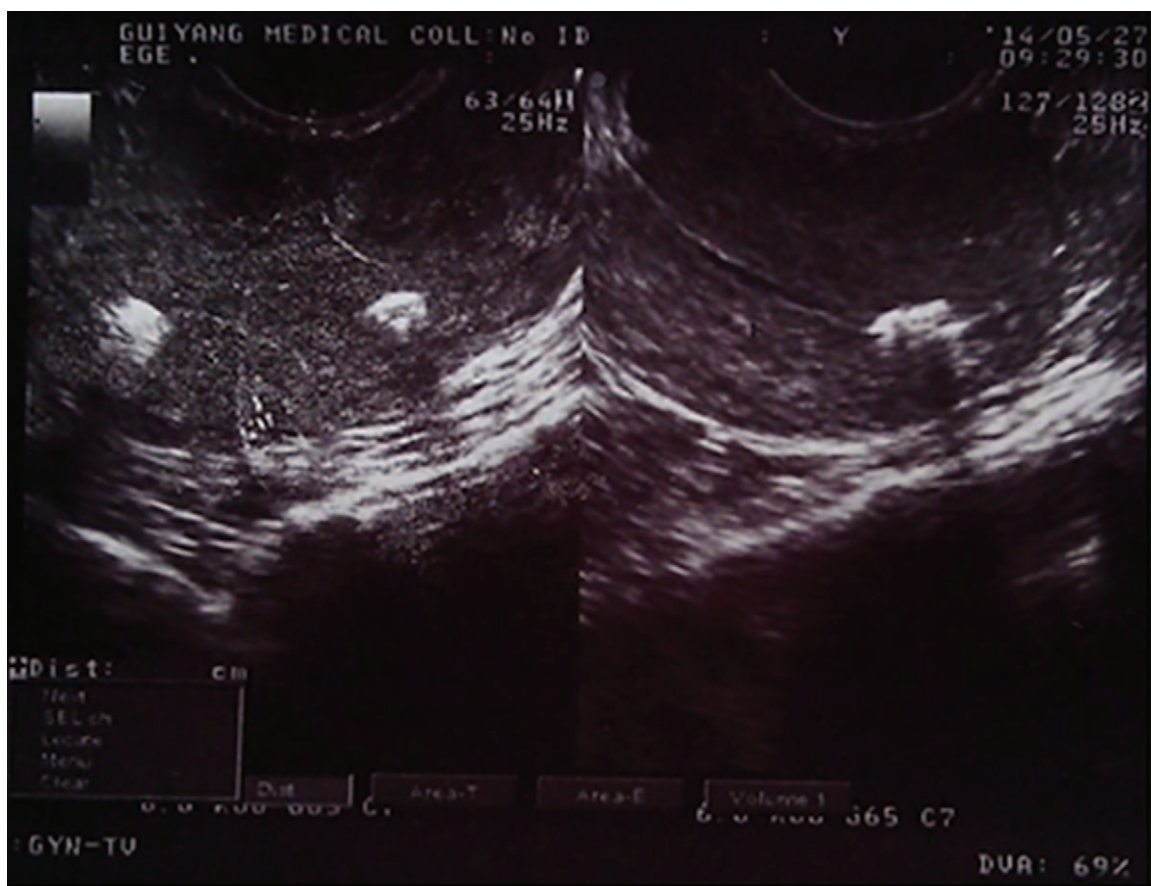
The ultrasonography after surgery.
